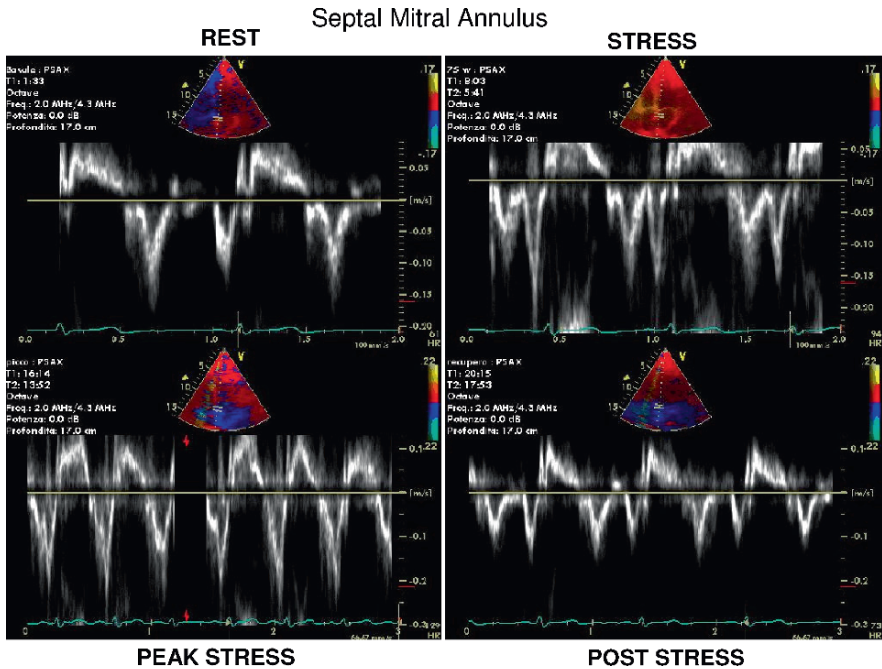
Tissue Doppler imaging of mitral annulus (septal side). The $2 E'$ and A' waves are clearly distinguishable at rest and in the recovery phase, but are fused (and uninterpretable) at peak stress
